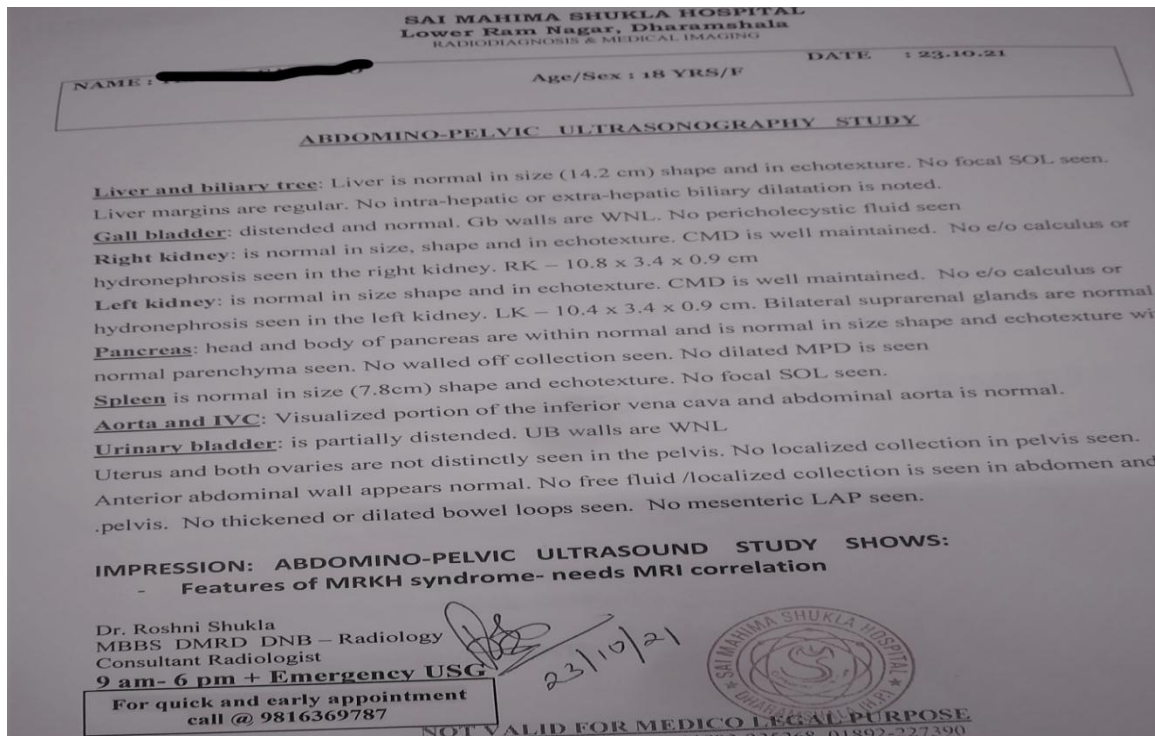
Ultrasonographic report showing MRKH Syndrome.
